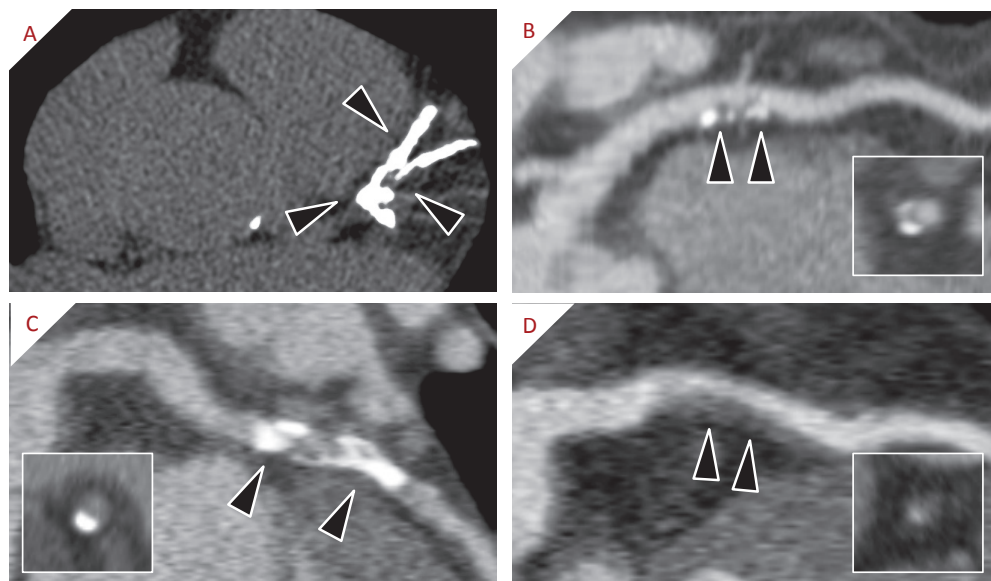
Visualization of coronary atherosclerotic plaques by computed tomography. (A) Visualization of coronary calcifications by means of contrast-free scan for coronary calcium scoring, demonstrating extensive calcification in the left anterior descending coronary artery and the first diagonal branch. (B - D) Curved multiplanar reconstructions of different types of coronary plaques, indicated by arrowheads, and with a cross sectional images. (B) A calcified plaque in the circumflex coronary artery, (C) a mixed plaque in the LAD, (D) a non-calcified coronary artery plaque in the LAD of a different patient.
